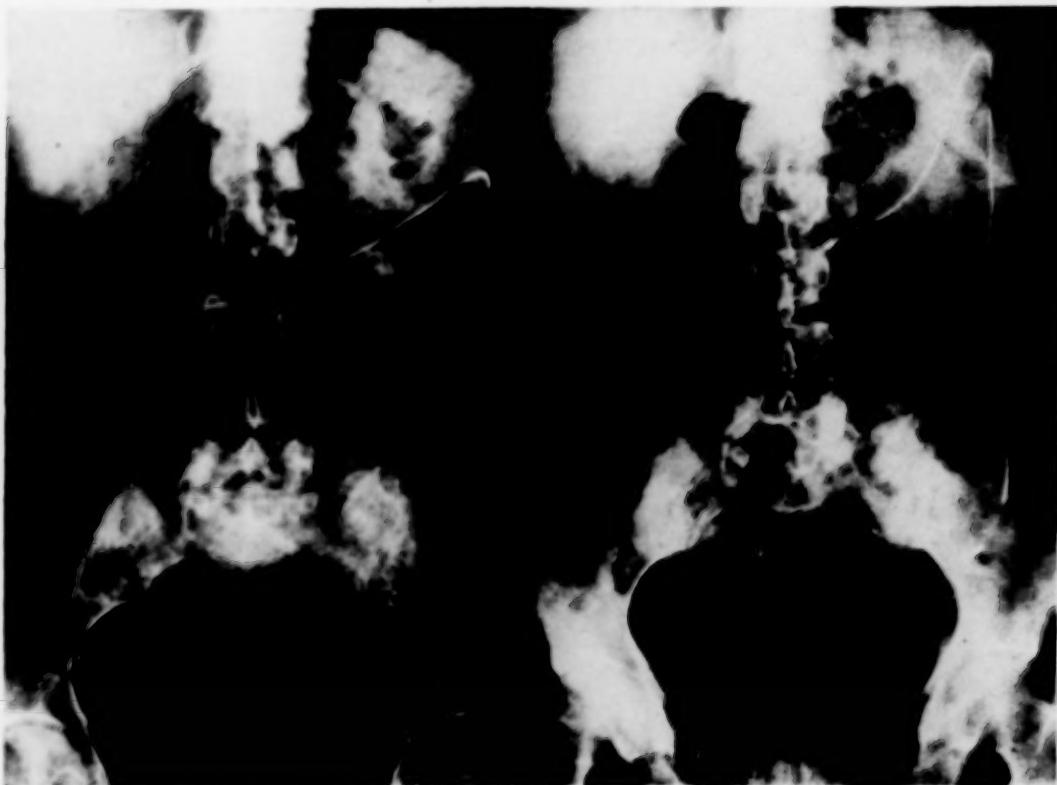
Roentgenograms showing polyethylene tubes in position. Left, clips next to openings are in cecum and descending colon. Right, clips in transverse colon and sigmoid.
